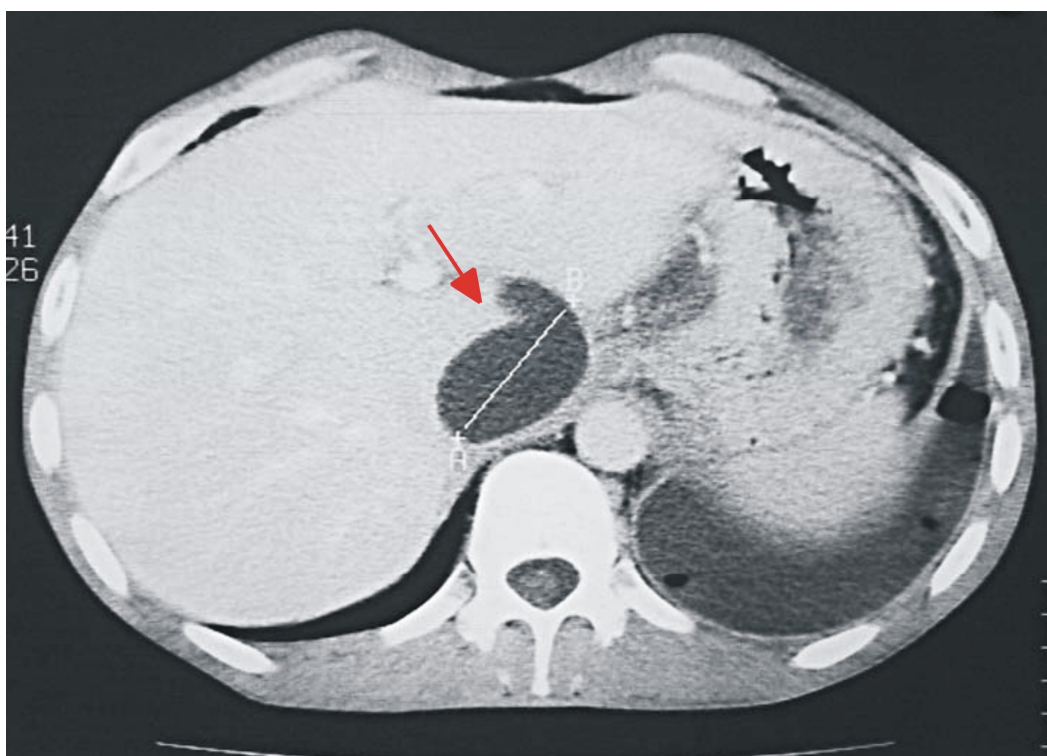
CT -- left-sided fluidothorax, subhepatic pseudocyst proximally communicating with the mediastinum.
